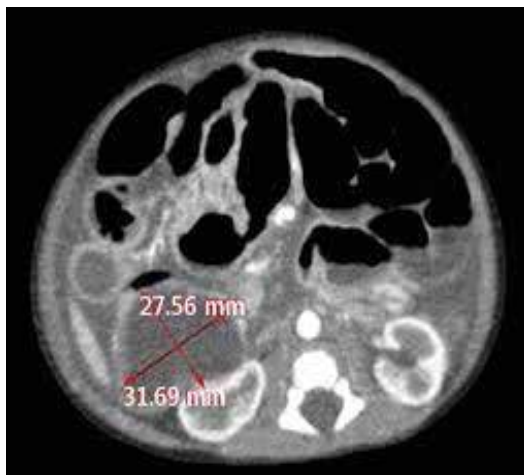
CT film showing the dimensions of the mass.
